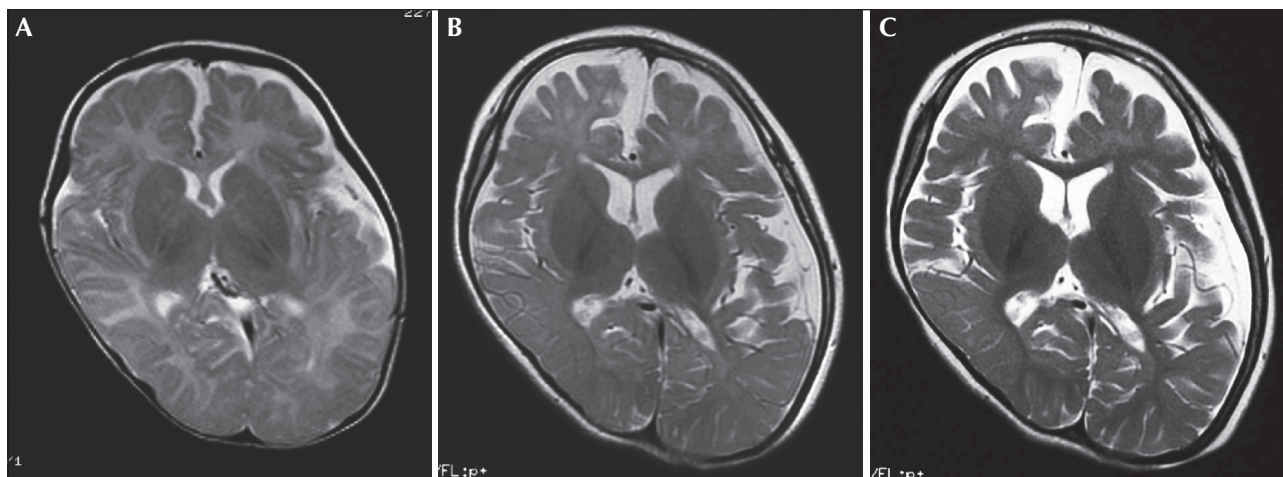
Brain MRI of patient. (A) A transverse T2-weighted image of the cerebrum at the age of 3 months shows slight atrophy in the left hemisphere. (B) A transverse T2-weighted image of the cerebrum at the age of 3 years and 8 months shows diffuse cortical atrophy in addition to white matter, particularly in the frontal lobe, a thin corpus callosum, and impaired myelination, particularly in the frontal lobe. (C) A transverse T2-weighted image of the cerebrum at the age of 6 years and 6 months shows progressive atrophy of the cortex, and a thin corpus callosum. Myelination of the hemispheric white matter is shown to have commenced gradually, especially in the occipital lobe.
